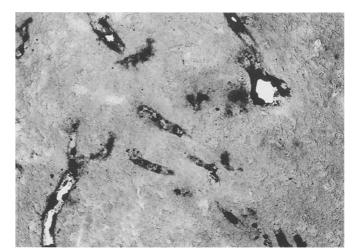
Findings on soft X-ray radiographs. LPD, which is deposited selectively within the tumor, appears as fine linear structures arranged in irregular and complex patterns corresponding to a cast of the tumor blood vessels
